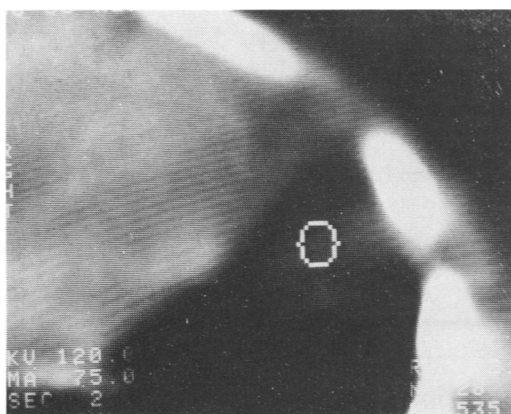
Computed tomography scan (enlargement) after intravenous contrast, showing no enhancement of the lesion.
